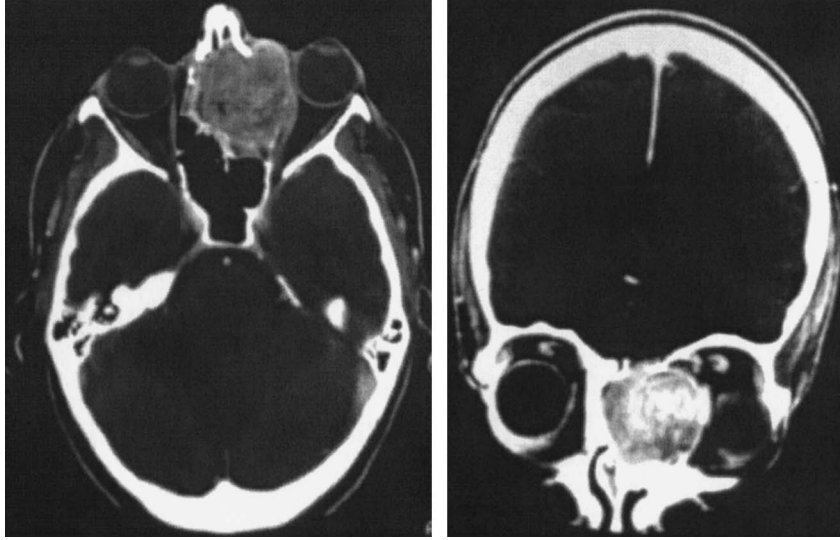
Preoperative (A) axial and (B) coronal CT showing an ethmoidal tumor invading the orbital cavity and eroding the lamina cribra.
